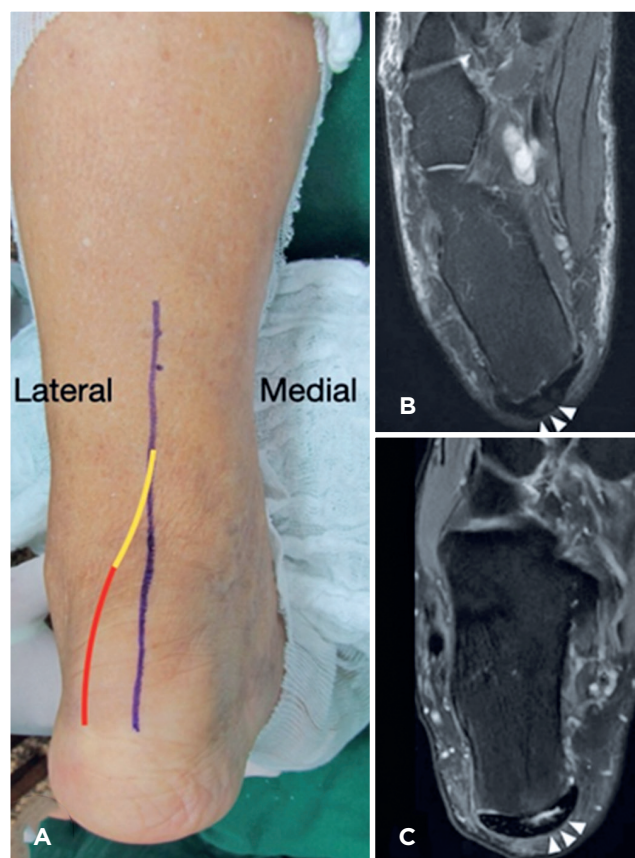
A) Demonstration of the central posterior approach (blue line). The posterior lateral approach (red line) and the proximal extension of this approach if necessary (yellow line); B) Axial magnetic resonance imaging showing the lateral localization of the calcifications (white arrowheads); C) Axial magnetic resonance imaging showing the medial localization of the calcifications (white arrowheads).
